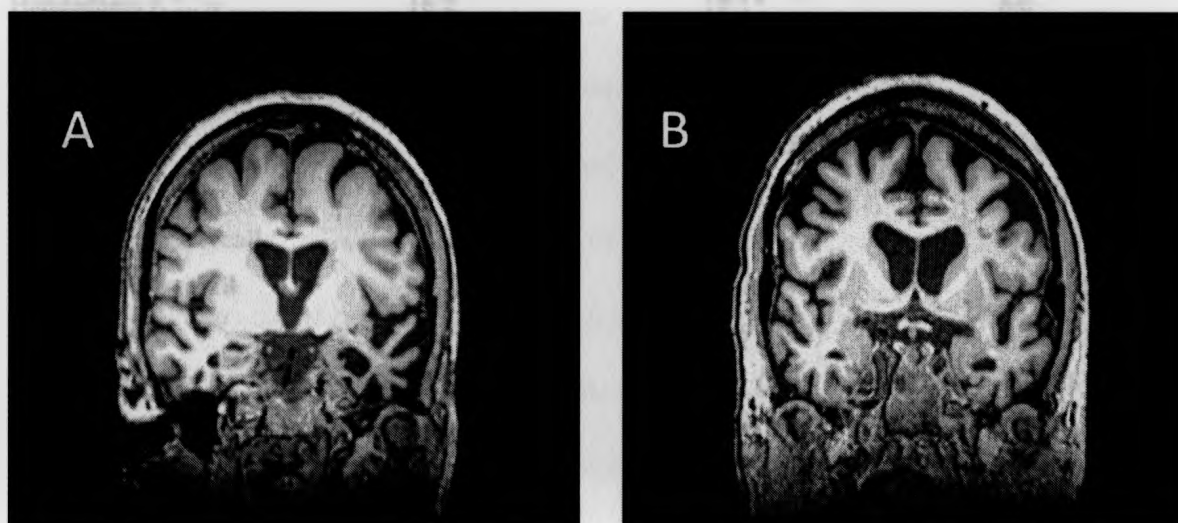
MRI pictures of bvFTD patients included in the present study (left side = right hemisphere; coronal slices). (A) 71 year old female bvFTD patient with semantic deficits, approximately 4.5 years post symptoms onset, demonstrating predominantly temporal lobe atrophy, left greater than right. (B) 61 year old male bvFTD patient without semantic deficits, approximately 7 years post symptoms onset, demonstrating predominantly frontal lobe atrophy.
